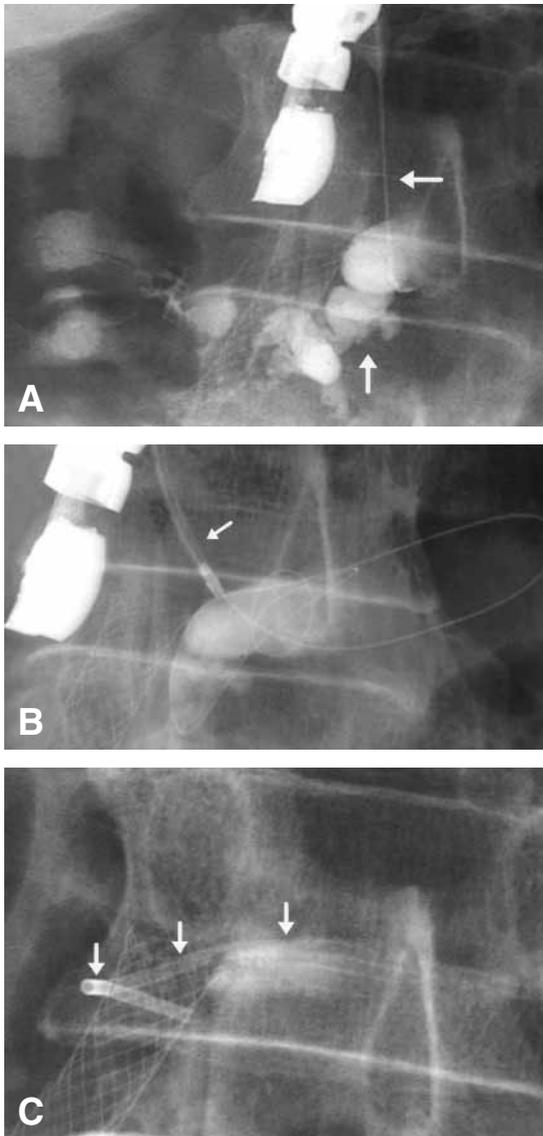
Patient 1. A, Radiograph showing echoendoscope with needle (*horizontal arrow*) entering pancreatic duct, which is partially opacified (*vertical arrow*). The metal biliary stent placed 9 years earlier is apparent. B, Radiograph showing diathermic sheath (*arrow*) introduced over a guidewire (looped in pancreatic duct). C, Radiograph showing pancreaticogastric stent (*arrows*).
